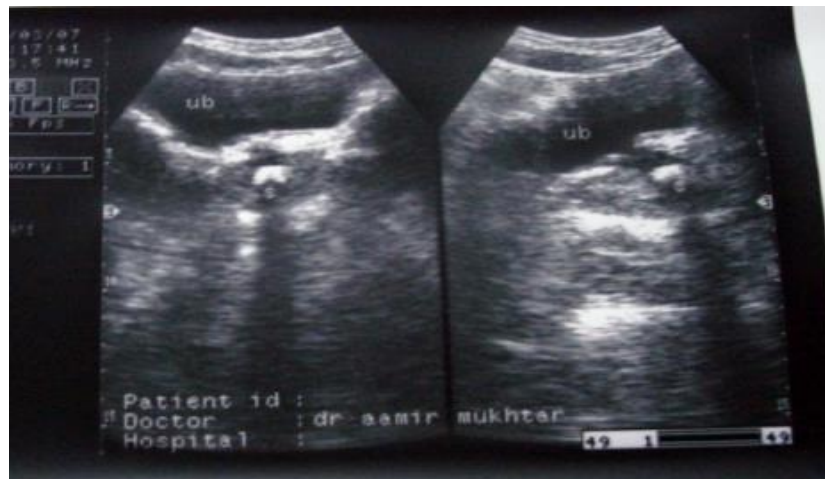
Shows a transabdominal ultrasound image of chronic prostatitis Verhamme et al., (2002).
